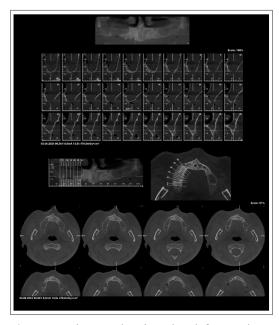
CBCT image showing the defect and associated chronic sinusitis
